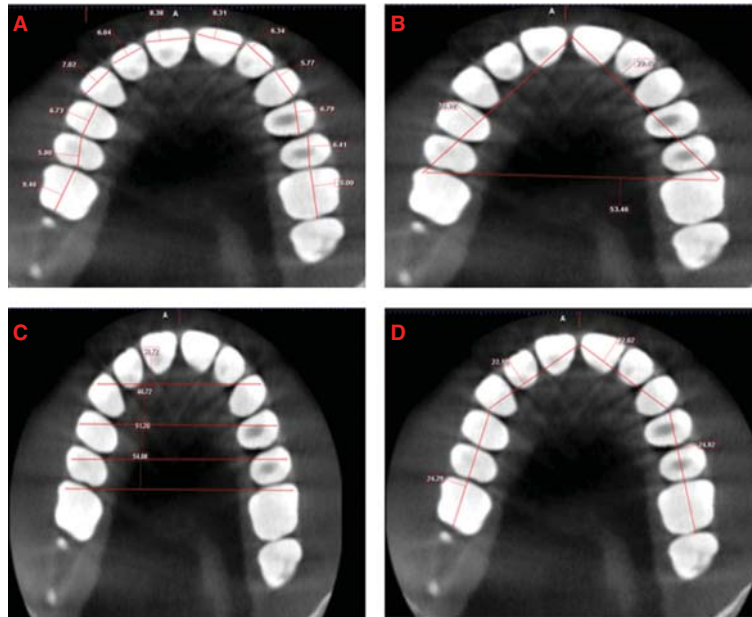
CBCT measurements of (A) Tooth size, (B) Arch width, (C) Arch length and (D) Arch perimeter.
